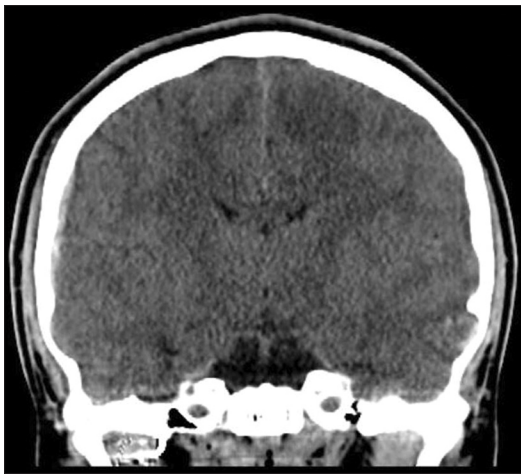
Postembolization coronal plane reformatted CT image postprocedure day 1 demonstrating markedly decreased size of the hematoma.
